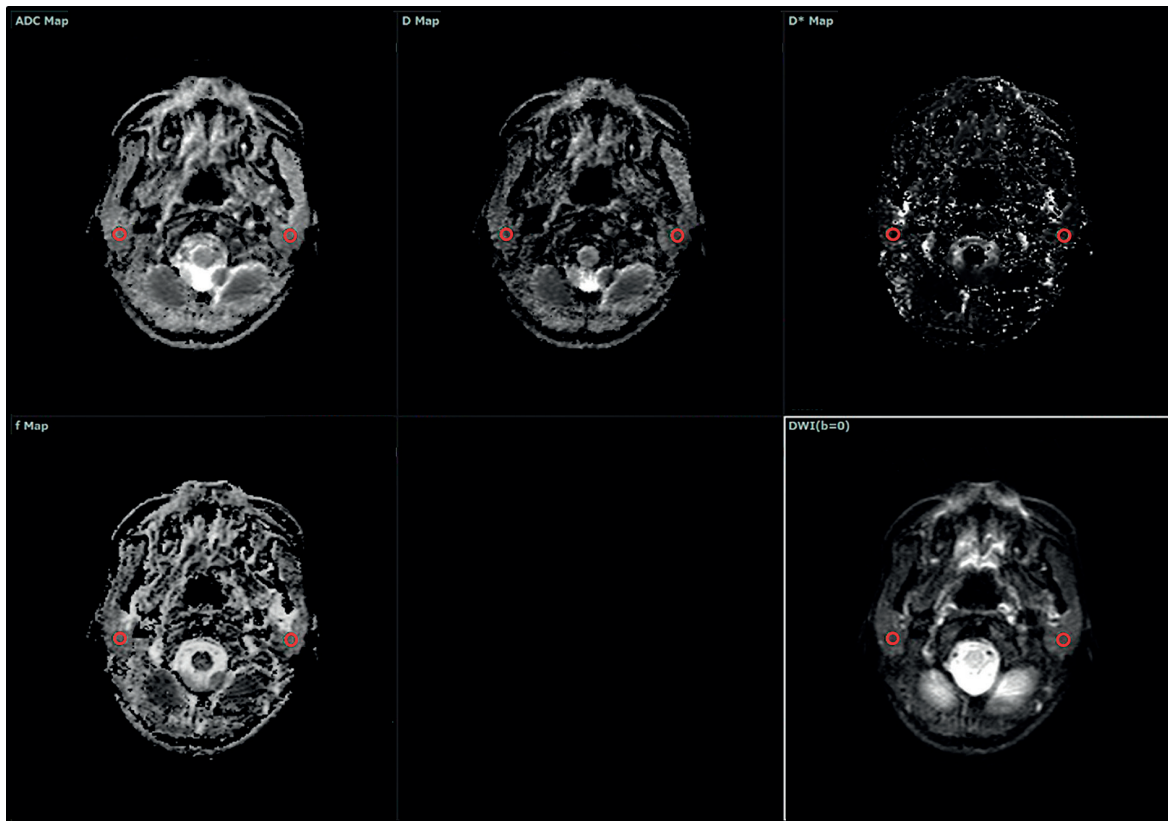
Regions of interest (ROIs) in an apparent diffusion coefficient (ADC) map, D map, D* map, f map, and diffusion-weighted imaging (DWI) at a b -value of 0 s/mm^2 in the bilateral parotid glands. A radiologic technologist manually set the ROIs in the bilateral parotid glands in DWI at a b -value of 0 s/mm^2 . The size of the ROI is 39.5 mm^2 . The ROIs were copied automatically on an ADC map, D map, D* map, and f map
